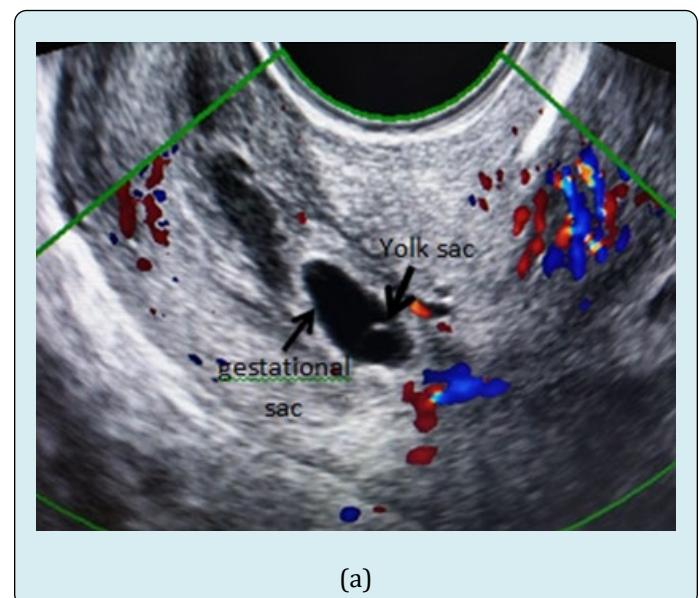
Ultrasonography image of a multiparous woman who presented with torrential and intractable bleeding in shock, showing distended cervix.
